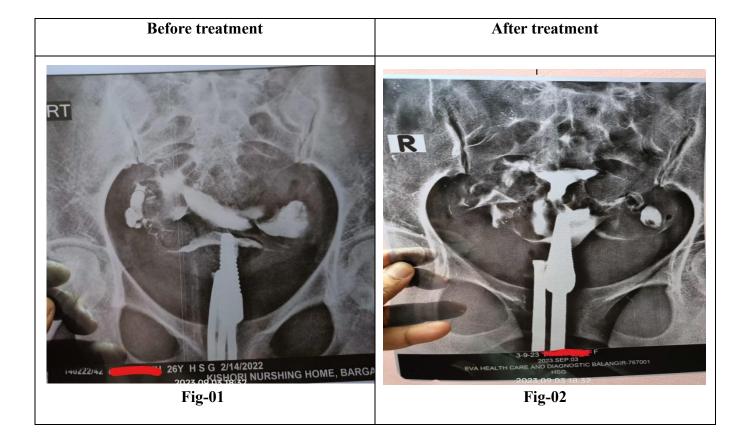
Showing Hysterosalpingography X-Ray before and after treatment
